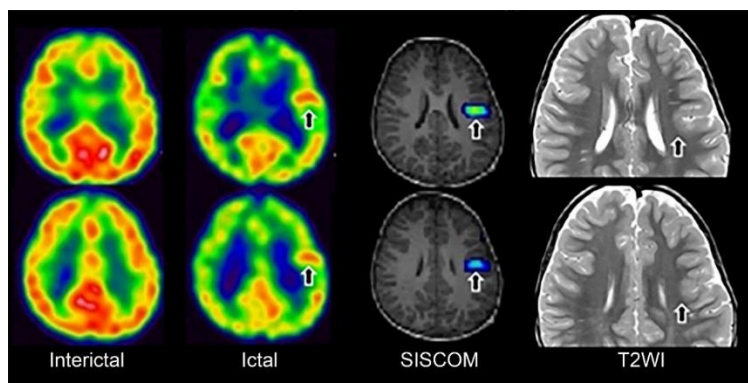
An imaging dataset of a three-year-old boy with intractable epilepsy, including interictal SPECT images (1st column), ictal SPECT images (2nd column), SISCOM images with ictal-interictal subtraction image fused with T1-weighted MRI (3rd column), and T2-weighted MRI images (4th column). In this case, the abnormal area identified by SISCOM technique (arrow) corresponds to focal cortical dysplasia type II as demonstrated in T2-weighted MRI images (arrow). Image courtesy of Yukio Kimura, M.D., National Center of Neurology and Psychiatry, Japan (with permission)
